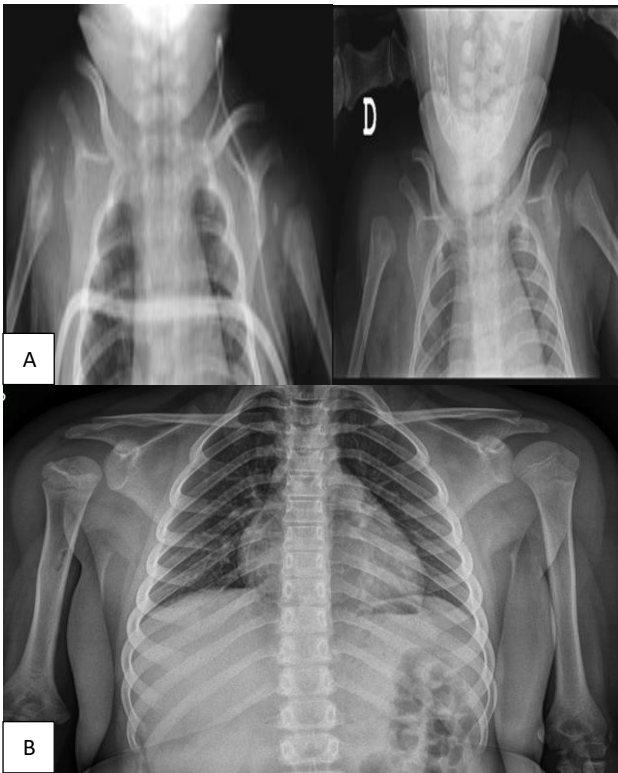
(A and B): Patient 6; initial antero-posterior radiographs of the shoulders; antero-posterior radiographs of the shoulders at time of last follow-up.
